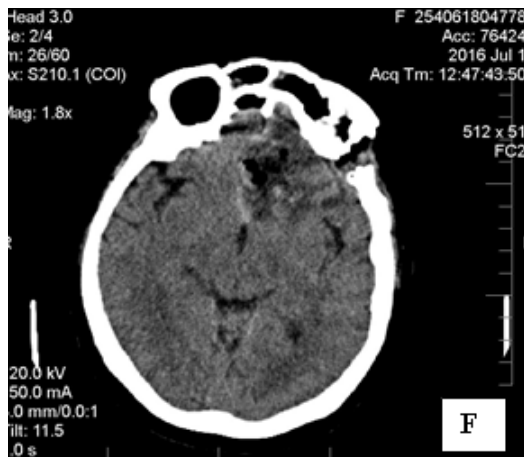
A, B – MRI images on sagittal and coronal view showing a planum sphenoidale meningioma; C, D – CT – angiography showing an ACoA associated aneurysm; E, F – CT control showing complete resection of meningioma and aneurysm clip artifact
